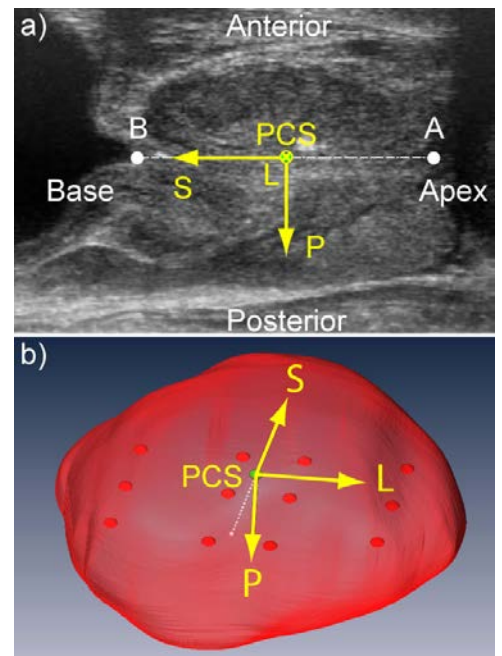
PCS Location: a) Central sagittal ultrasound through the prostate showing apex (A) and base (B) points, b) PCS with Left-Posterior-Superior coordinates.
